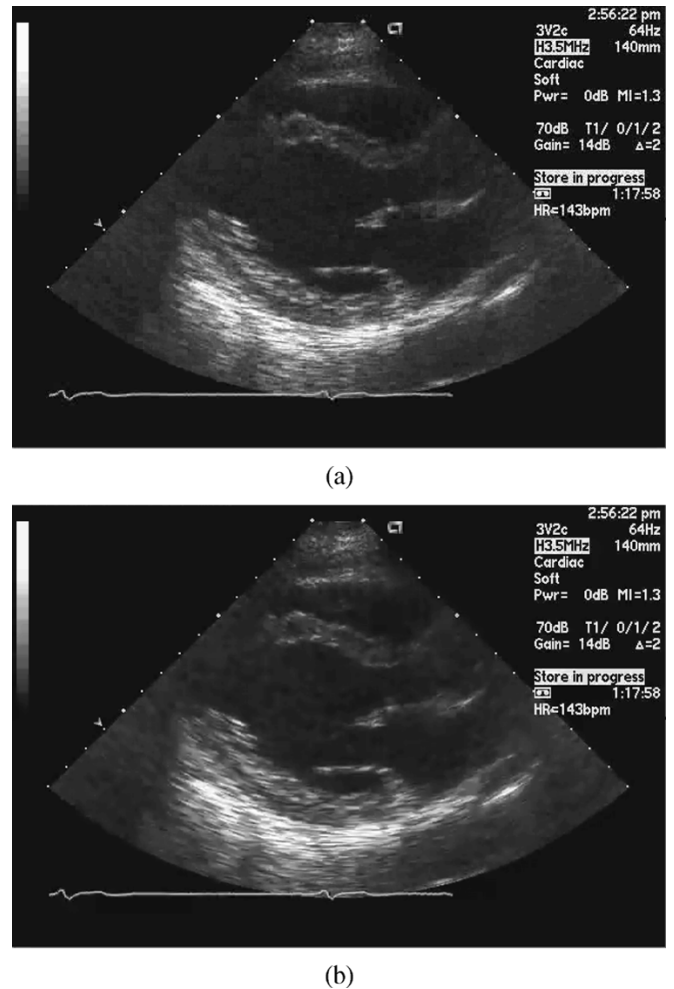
The reconstructed images of the 32nd frame of sequence "echocardiography" at bit rate of 667.08 kbps. (a) MPEG-4. (b) H.264.
